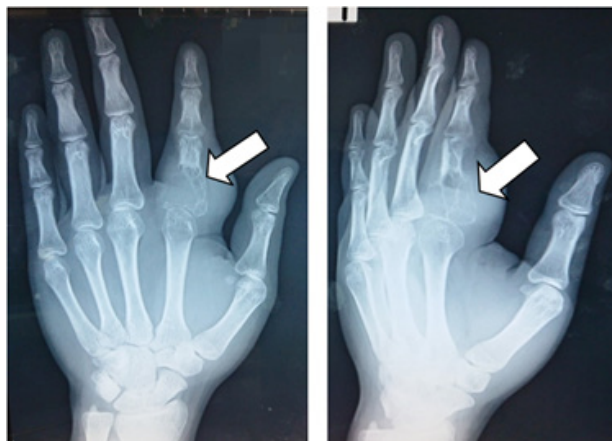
Pre-operative radiograph (posteroanterior and oblique views). The white arrow shows a lytic, eccentric, and geographic destruction type of lesion at the base of the proximal phalanx of the ring finger. The ill-defined margin of the lesion shows a focal destruction which suggested an aggressive behavior.
